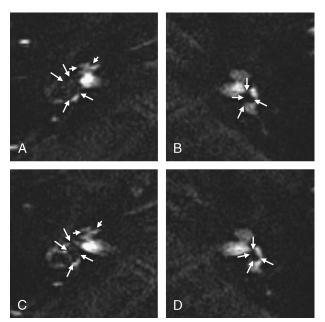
An example of endolymphatic hydrops on MRI. Consecutive sections of heavily T2 weighted 3D-FLAIR MRI taken 4 hours after intravenous standard-dose gadolinium injection in a patient with significant endolymphatic hydrops in the right cochlea. A and B, C and D, are the same sections. Significant endolymphatic hydrops was observed in the right cochlea (*short arrows* in A and C) but no endolymphatic hydrops was observed in the left cochlea (B and D). The vestibular endolymphatic hydrops on the right side was larger than that on the left side (*long arrows*).
